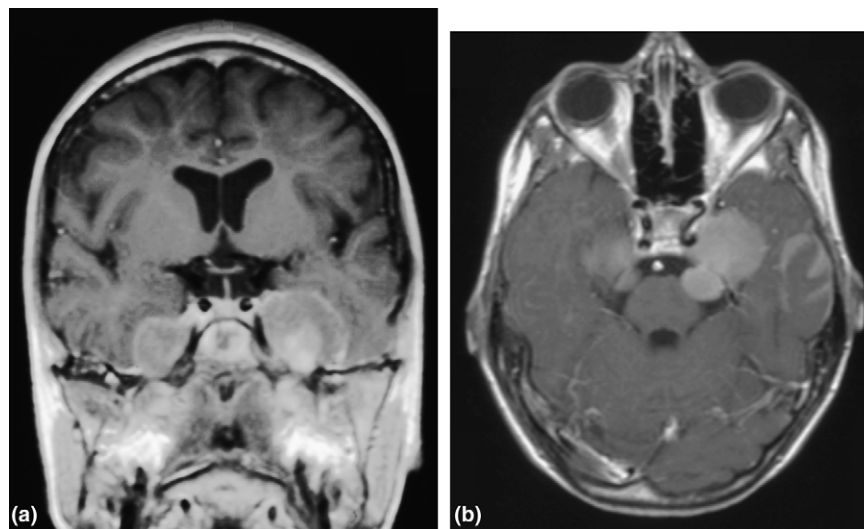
Case 6: 14-year-old boy 10 years after treatment for leukaemia who developed NHL (Non-Hodgkin's Lymphoma). (a): T1-weighted coronal view after contrast shows bilateral well-demarcated round, parasellar enhancing masses. (b): T1-weighted axial view, after contrast.
